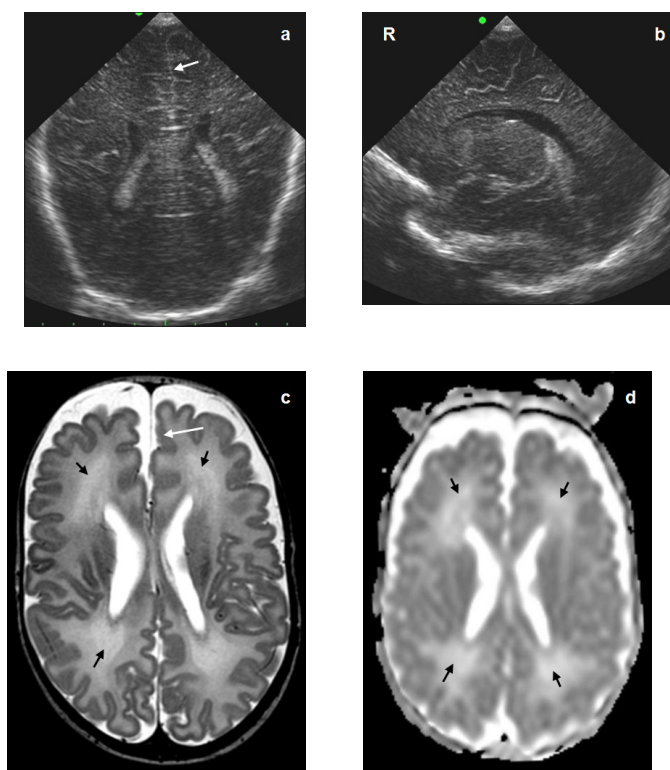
Coronal (a) and parasagittal (b) cUS scan of a preterm infant (gestational age 26.3 weeks) around term equivalent age (corrected gestational age 42.0 weeks, postnatal age 105 days) showing a widened interhemispheric fissure (arrow) and normal appearing brain white matter (classified as normal white matter). Transverse T_2 - (c) and diffusion-weighted (d) MR image at high ventricular level of the same infant, performed on the same day as the cUS scans, showing a widened interhemispheric fissure in the frontal region (long arrow). Also showing diffuse and excessive high signal intensity in the frontal and parieto-occipital white matter on the T_2 -weighted image (c, short arrows), and high signal in the frontal and parieto-occipital white matter on the diffusion-weighted image (d, short arrows). This infant had a mildly abnormal outcome at 2 years corrected age.
